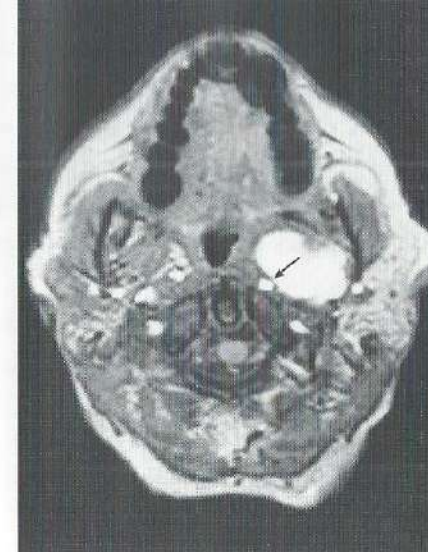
MR T1-weighted GE imaging enabled superior identification of the internal carotid artery that is visualized with a high signal intensity (arrow).
